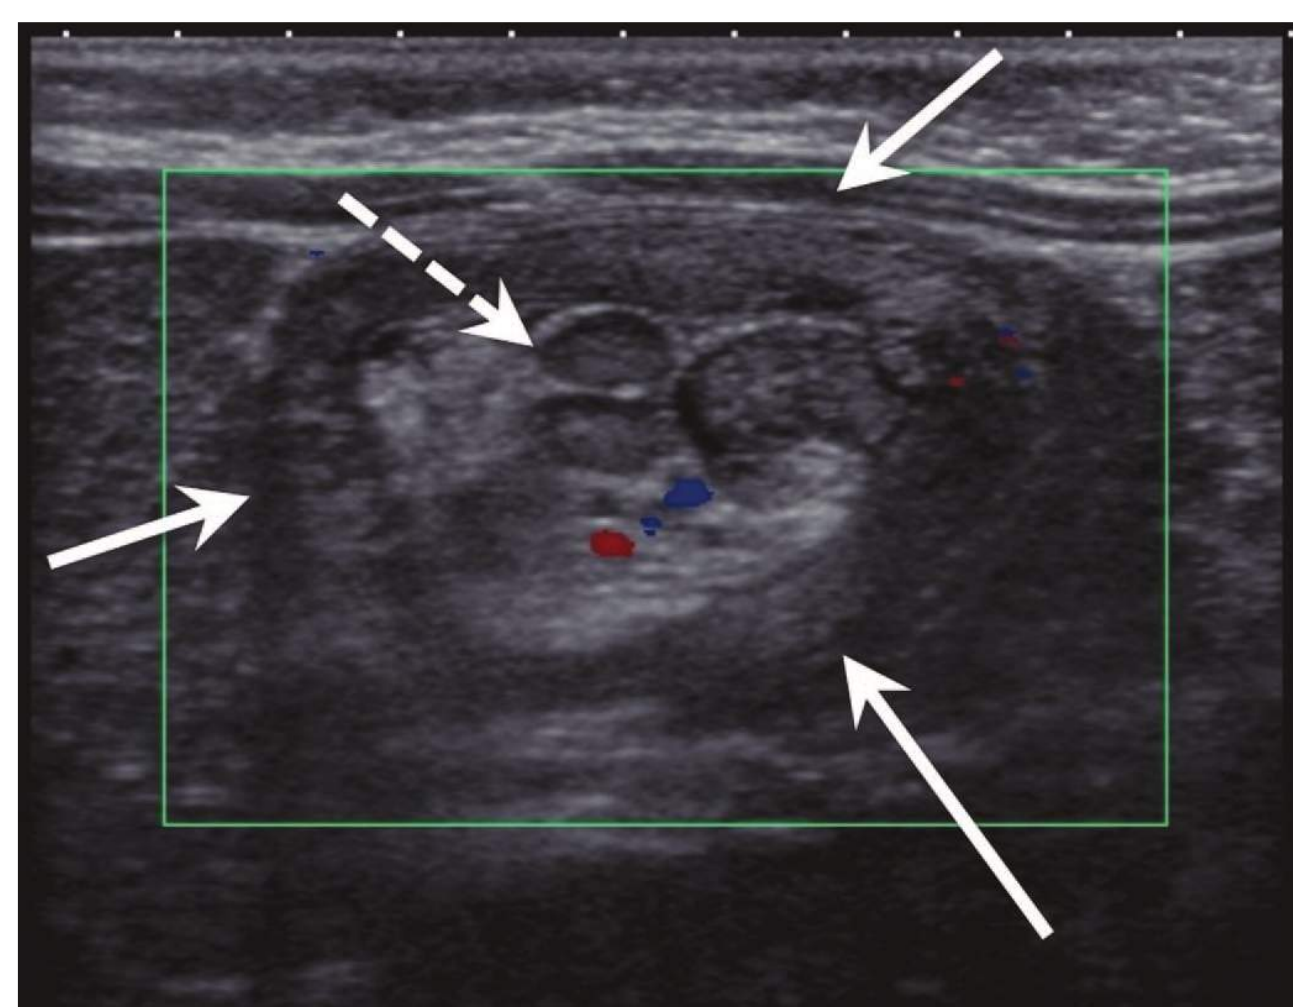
■ Ileocolic Intussusception. Ultrasound showing intussuscepti (arrows) containing echogenic fat and multiple lymph nodes (dashed arrow). (Photo contributor: Alexander Towbin, MD.)
